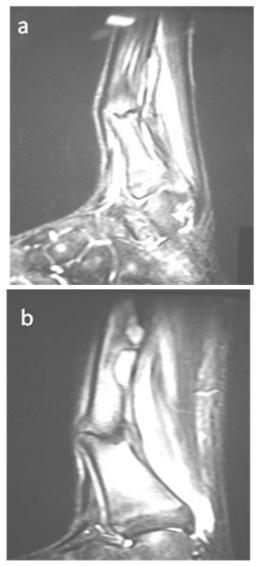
Fig 15ab: MRI – Pseudoarthrosis with neurofibromata.
